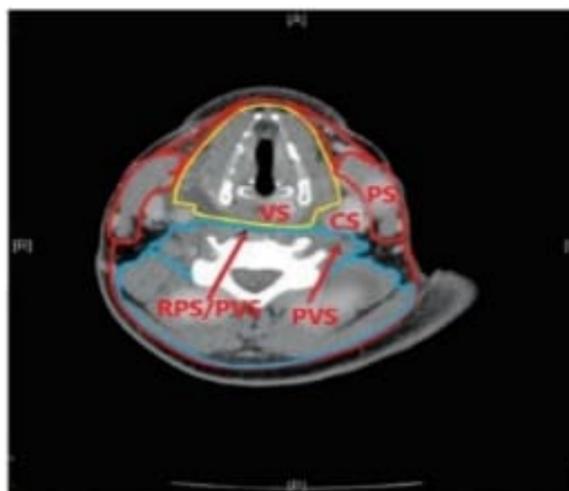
MRI Neck-axial section of infrahyoid spaces; 3 layers of DCF- colour code as above; VS-Visceral space. (Courtesy: [www.entokey.com](http://www.entokey.com))
